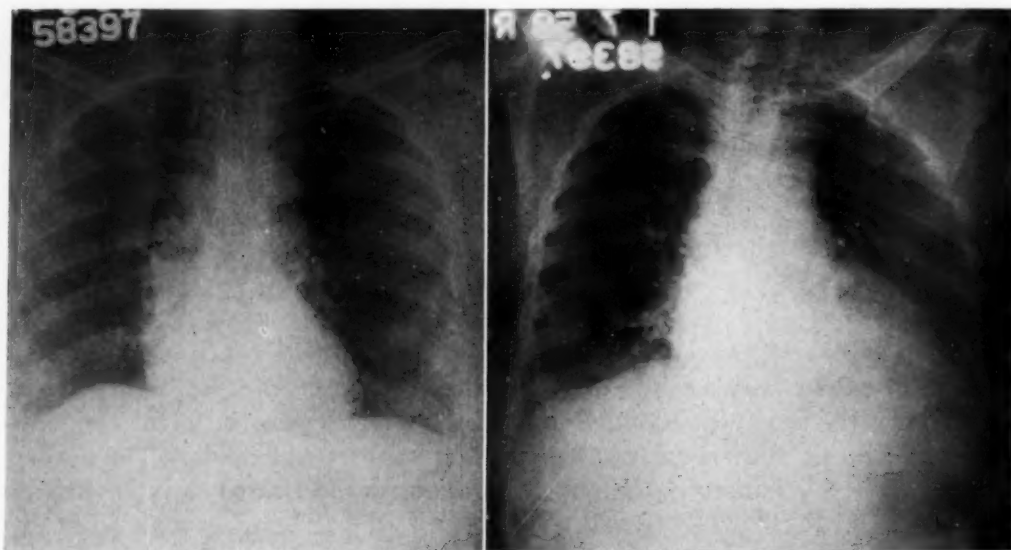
X-rays of the chest showing the change in cardiac size and contour between initial and final admissions.
